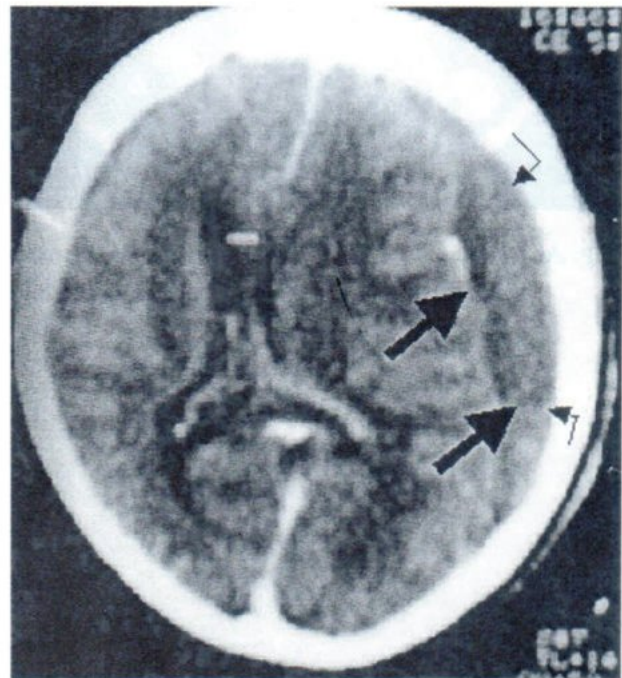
B Contrast enhanced CT.
